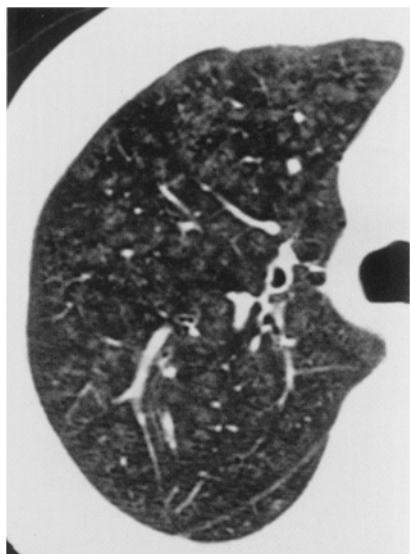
HRCT scan of siderosis. Ill-defined centrilobular nodular areas of ground-glass attenuation diffusely distribute throughout the lung. The HRCT appearance resembles that of hypersensitivity pneumonitis
